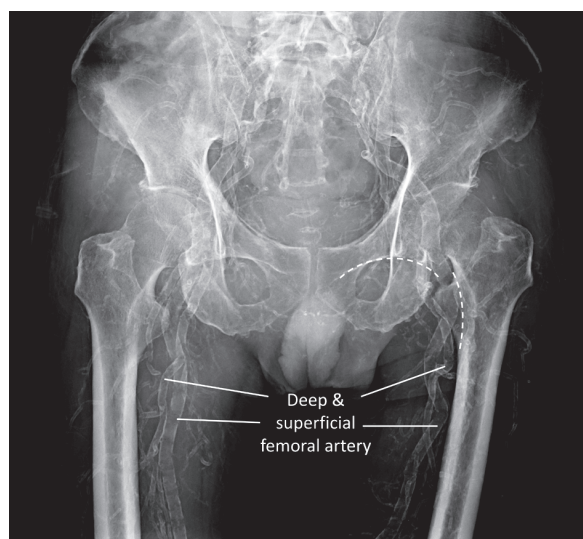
Pelvic plain radiograph showing disruption of Shenton's line on the left hip (dotted line), indicating left femoral neck fracture. Note the diffuse noticeable vascular calcification involving internal and external iliac as well as superficial and deep femoral arteries.
